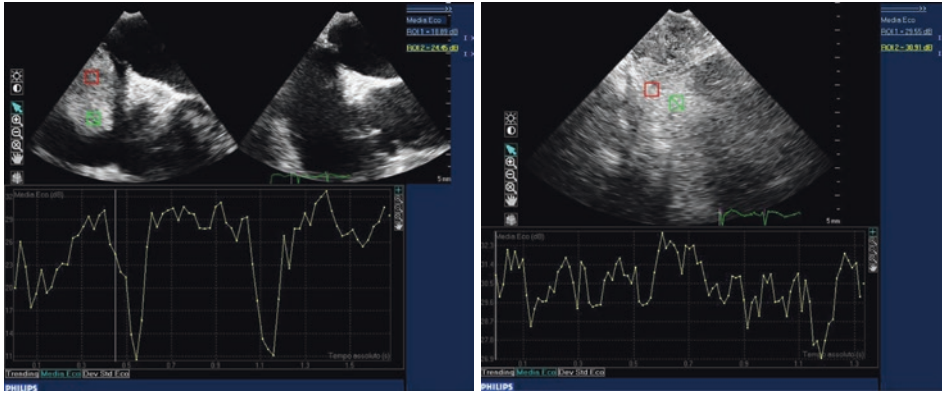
Right atrial mass. Transesophageal echocardiography. Quantitative analysis of time-intensity curve obtained by quantification software with estimation of myocardial blood volume in two regions of interest (*red* and *green*) during contrast enhancement. The increase of decibel depends on rich vascularization of the mass (myxoma)
